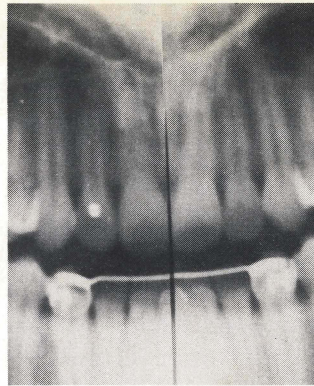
Radiographic appearance after eighteen months of orthodontic therapy. The excellent alignment is stabilized by a fixed mandibular holding arch.
